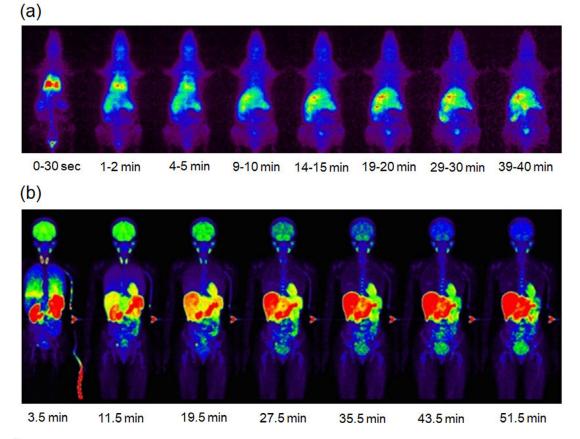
Imaging parasympathetic innervation on myocardium. Serial coronal images were acquired by means of PET-CT after intravenous injection of ¹¹C-labeled Donepezil hydrochloride, an acetylcholine esterase inhibitor which is prescribed to patients with Alzheimer's disease. Note an elevated accumulation of the ligand in myocardium rather than a target organ of brain.
